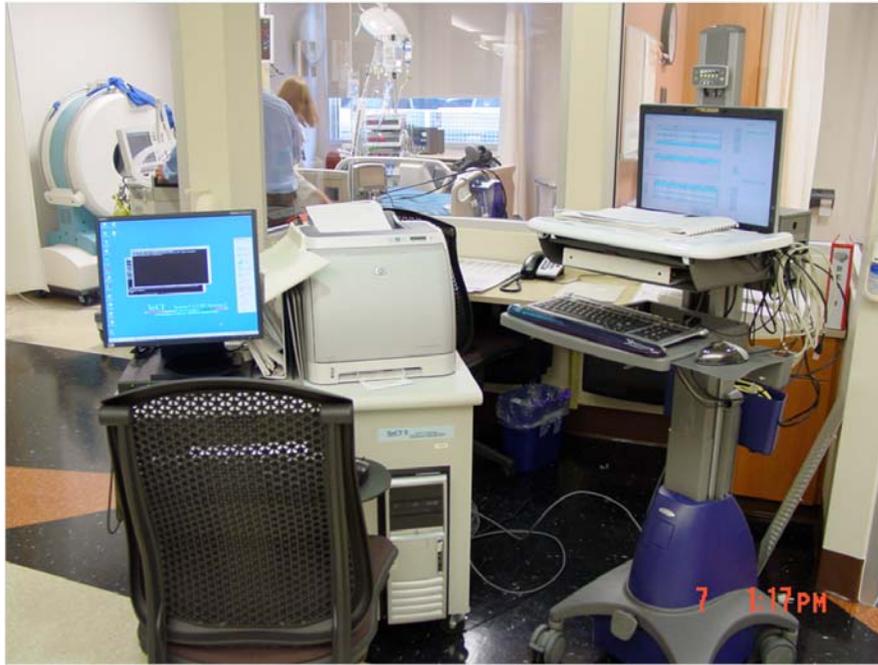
The bedside set-up to perform a xenon/CT study in the intensive care unit. The portable CT scanner is seen in the upper left at the patient's bedside, and the control station for the scanner is the rolling stand on the right. The xenon administration and analysis unit is in the foreground to the left.
